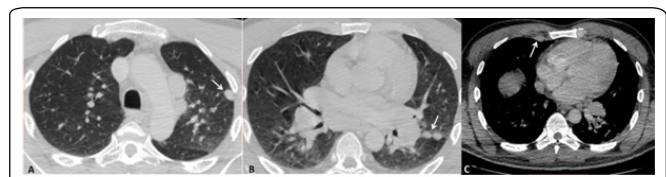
Chest CT acquisition at the axial plane (A, B), reveals the presence of pulmonary nodules in the apico-posterior segment of the left upper lobe and in the left major fissure (arrows). There was also a right anterior pleural nodule with enhancement (C, arrow).
